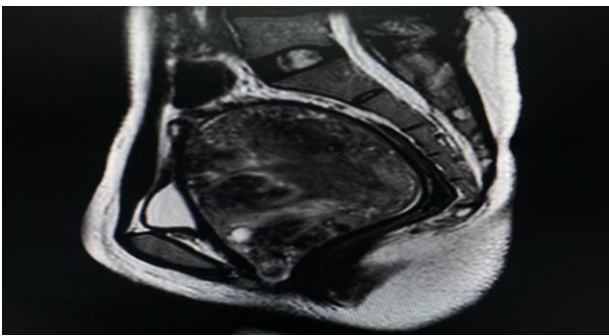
MRI film showing the sagittal section in which the upper end of the mass is reaching the sacral promontory.
